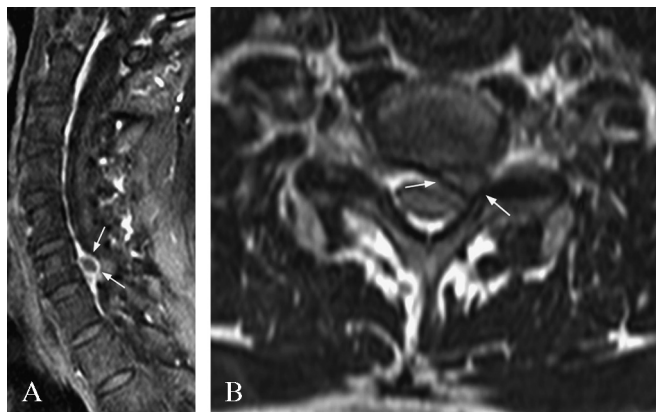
A) The lesion showed peripheral enhancement on contrast enhanced T1-weighted sagittal image which is in favor of sequestration (arrow); B) T2-weighted axial image shows the lesion isointense with the nucleus pulposus and spinal cord (arrow). There is obliteration of subarachnoid space, left mediolateral cord compression and narrowing of left neural foramen.
